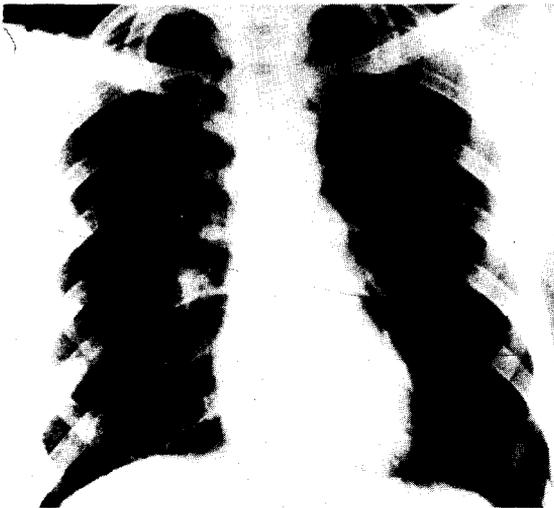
Chest x-ray. One week after the infecting bathe. The same appearance was observed 6 weeks after the infecting bathe.
